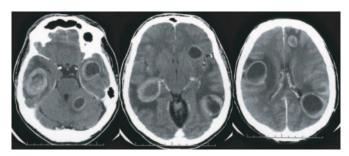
Axial cranial computed tomography with contrast injection (slide thickness 3 mm): multiple round, cystic space occupying lesions with central hypodensity, perifocal edema, mass effect and marginal contrast enhancement frontal, fronto-temporal and parietal. Maximal size: 4.5 cm.
